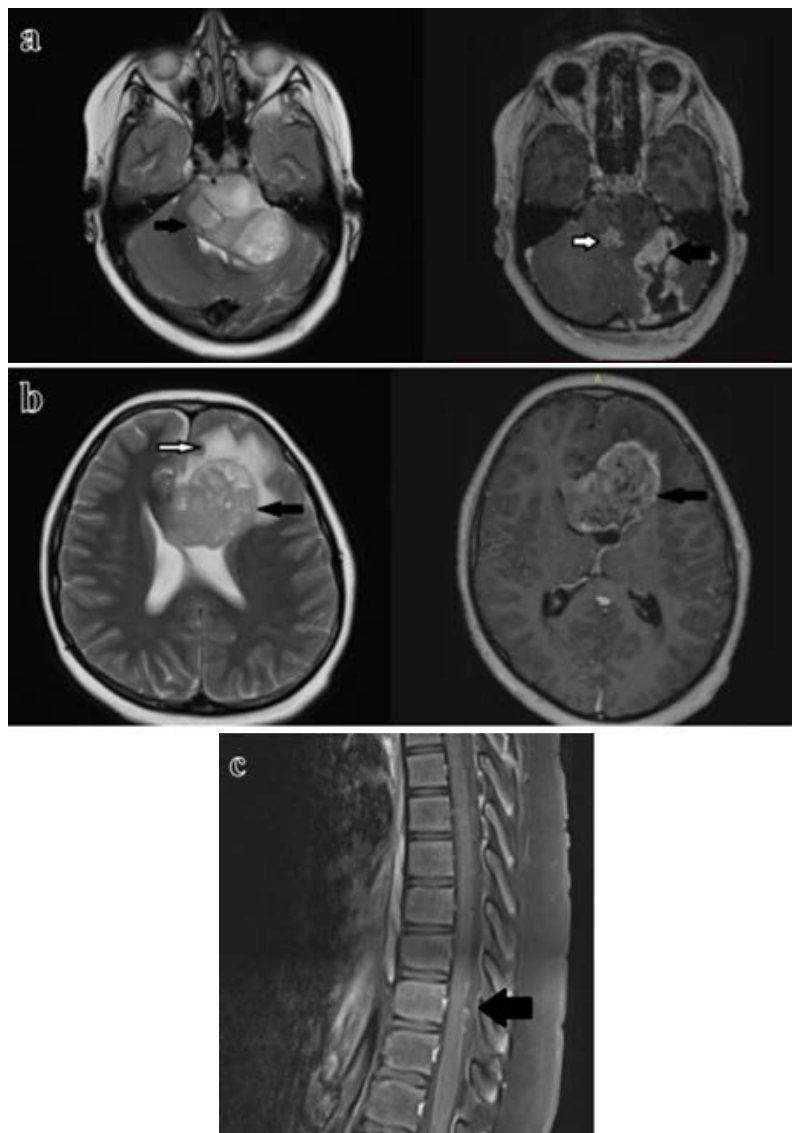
Postoperative brain and spine magnetic resonance imaging. a) A postoperative cavity with the presence of a residual tumor that is adherent to the cavity wall (black arrow, right). Diffuse infiltration of the pons (black arrow, left) with a demarked T1 postcontrast lesion (white arrow, right). b) Significant progression of the frontal lesion (black arrows, left and right) with contralateral propagation and infiltration of the anterior portion of the corpus callosum (white arrow, left). c) On T1 postcontrast images, three nodules at the level of Th10 and Th11 vertebral bodies are highly suspicious for leptomeningeal dissemination (black arrow).
